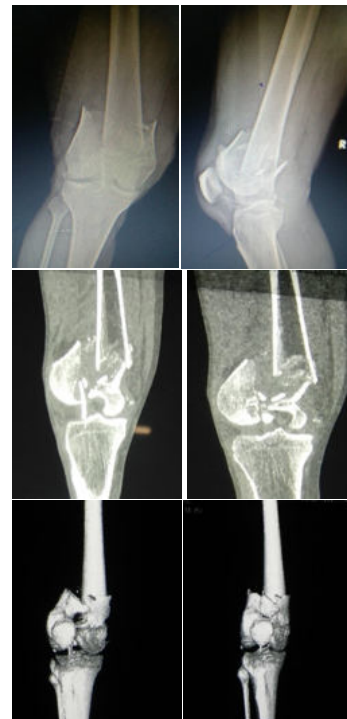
Pre op X ray and CT images
